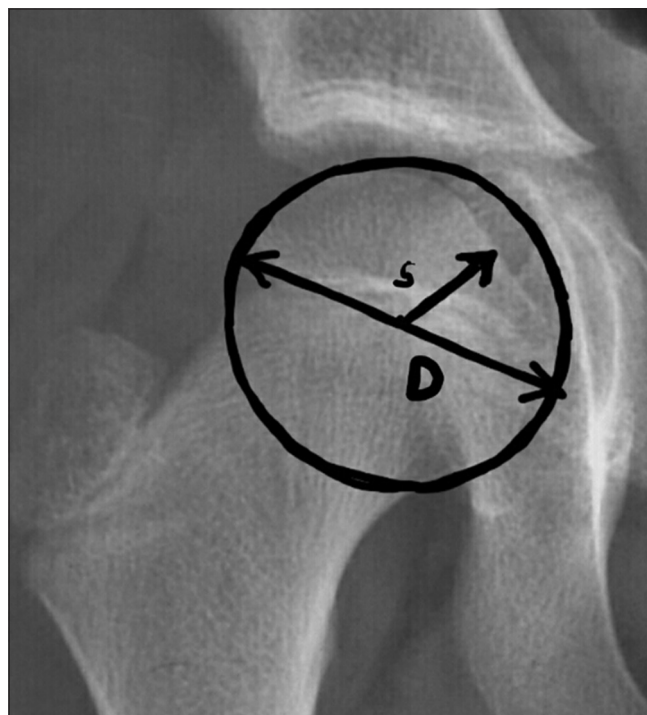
X-ray (right) hip joint anteroposterior view showing, "D" the maximum diameter of the head and "s" the minimum radius from the middle of D to the surface of the femoral head
